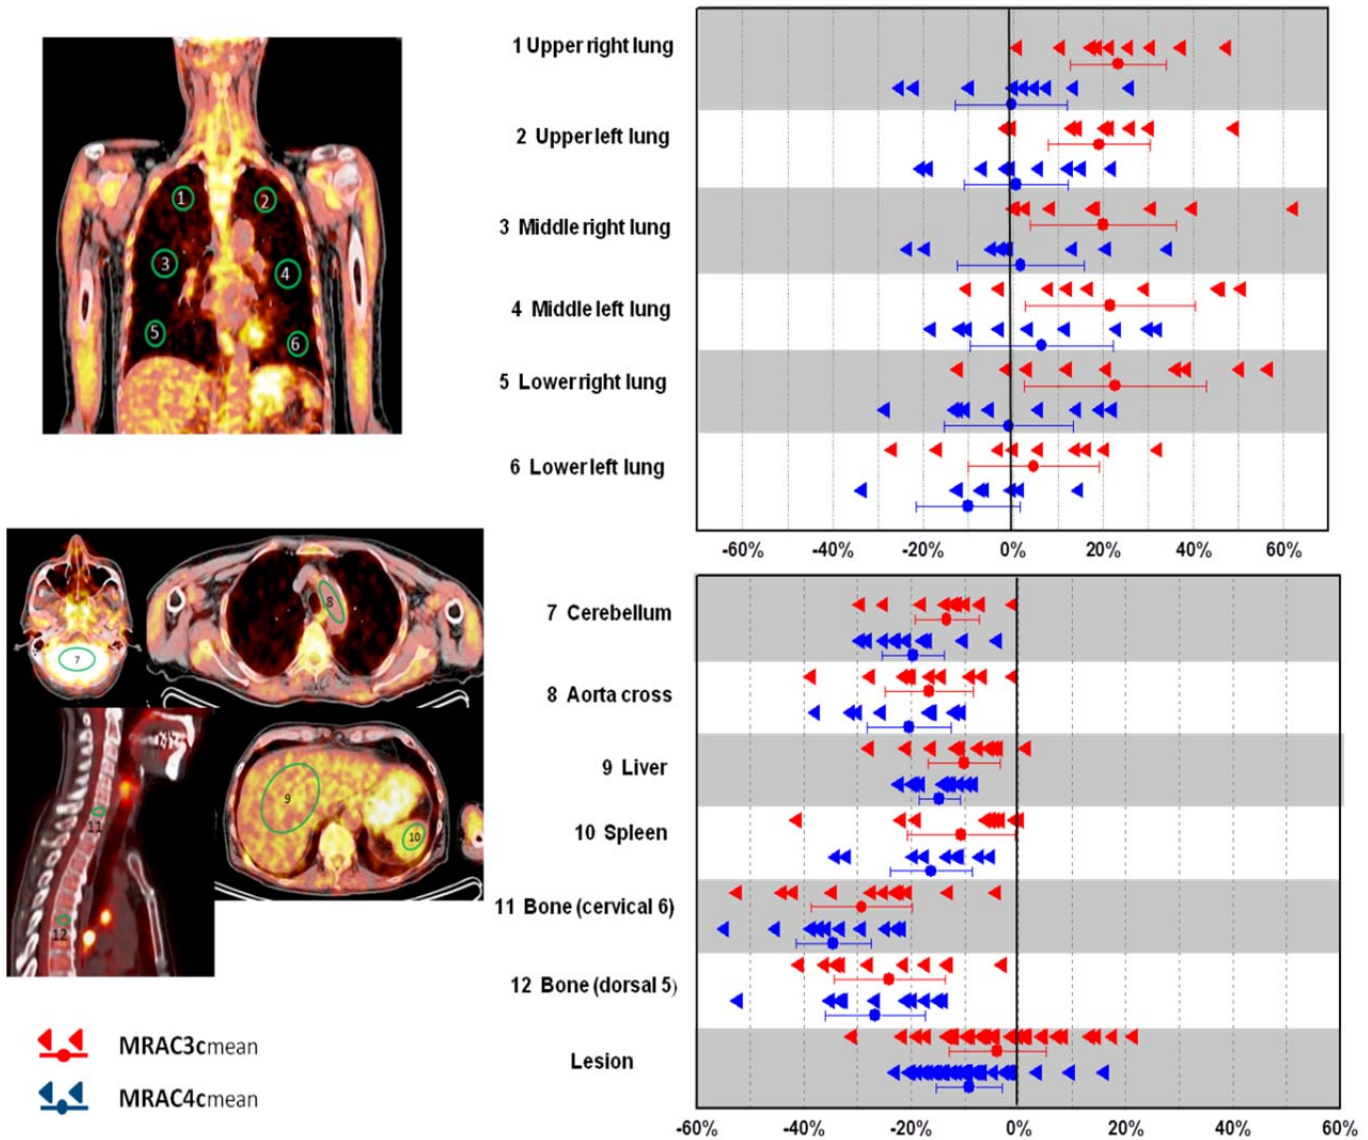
Relative errors between SUVmean estimated using PET images corrected for attenuation using three- (PET-MRAC3c) and four-class (PET-MRAC4c) based MR-guided attenuation correction compared to CT-based attenuation correction (PET-CTAC) for different organs. The dot point and line bar indicate the mean and standard deviation of the results, respectively.
